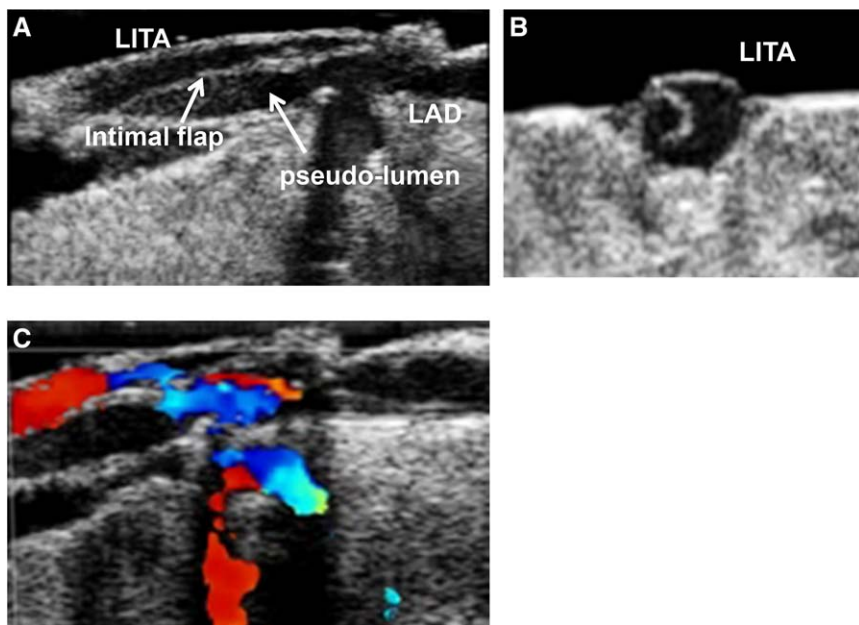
Intraoperative detection of an intimal flap of the LITA at the coronary anastomosis by using 15-MHz high-frequency epicardial ultrasound. A, Longitudinal view of the LITA-LAD anastomosis. B, Transverse view of dissection of the LITA. C, Doppler color flow mapping detected the restricted flow in the true lumen (longitudinal view). LAD indicates left anterior descending artery; and LITA, left internal thoracic artery;
